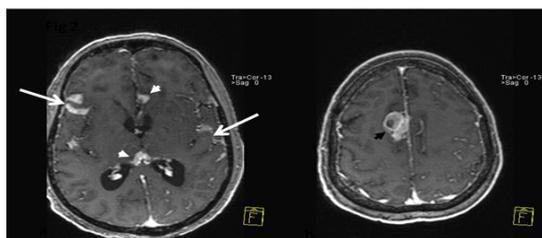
(A-B). Post-contrast Axial reformatted T1 weighted MR images of the brain at the level of the sylvian fissures (A) and the cerebral convexities (B) reveal well-defined enhancing lepto-meningeal plaques in the sylvian fissures (white arrows), right parafalcine region (black arrowhead) and in the inter-hemispheric fissure (white arrowheads)
